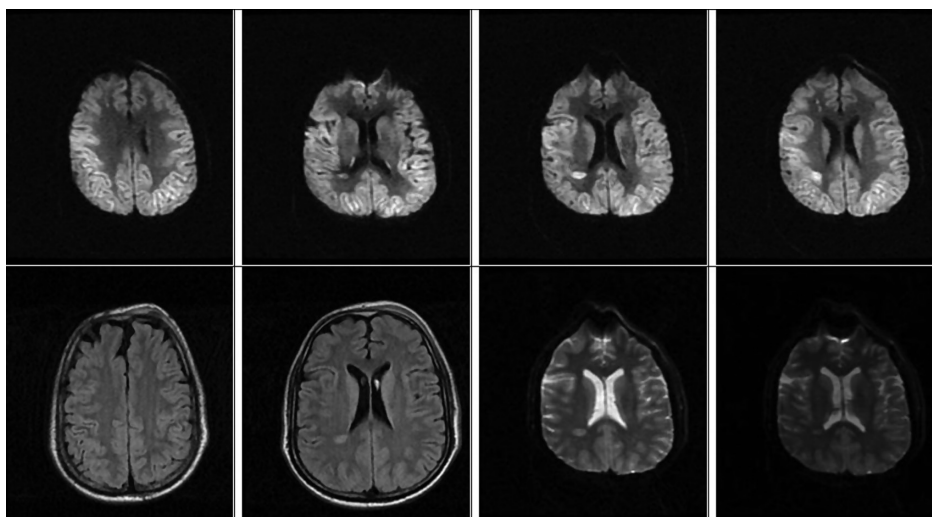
13 × 19 mm hyperintense lesion on T2-weighted magnetic resonance was observed in the right posterior periventricular white matter, and diffusion restriction was observed in this localization. Diffusion restriction was observed in the bilateral hemispheric cortical parenchyma, and the findings may be significant in terms of global hypoxic ischemia.
